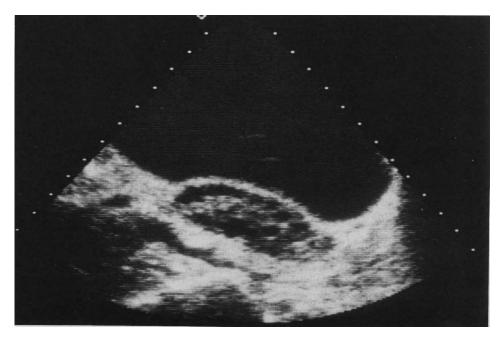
Ultrasound appearance of a polycystic ovary
